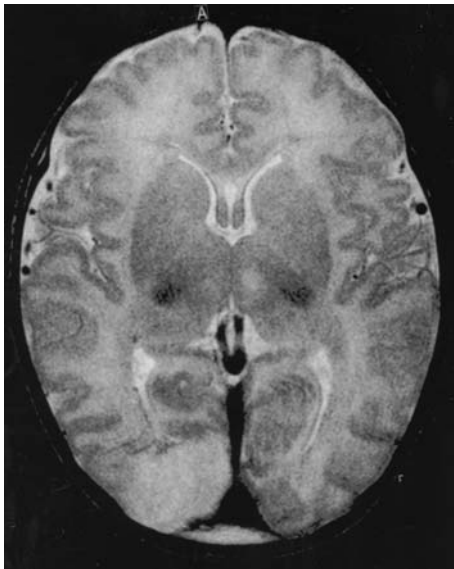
Axial T2-/FSE MRI at 1 day following severe perinatal asphyxia: blurred anatomy of basal ganglia. Localized signal alteration in right occipital lobe (necrosis)
